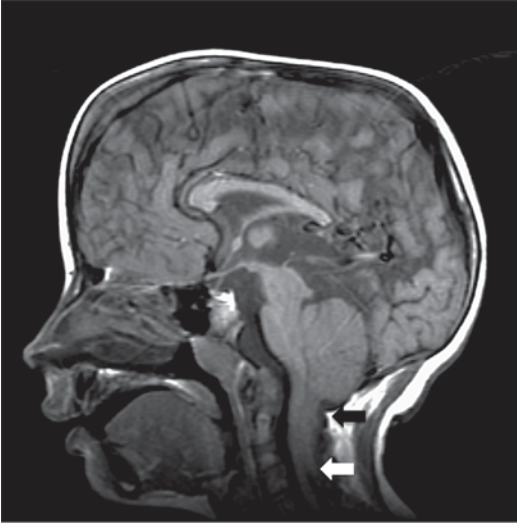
Sagittal T1 weighted MRI of Chiari type II showing: narrowed 4th ventricle, beaked tectum, hypoplastic corpus callosum, and low cerebellum (*white arrow*) below the foramen magnum (*black arrow*) (Courtesy of Blaine Hart, MD)
